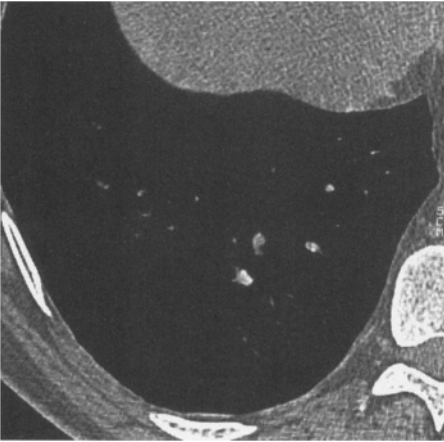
CT scan : subcostalis muscle
